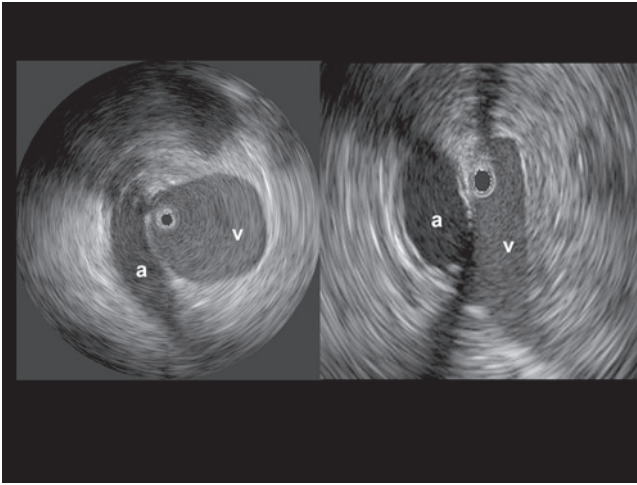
Images obtained by intravascular ultrasound (IVUS). The internal iliac artery (a) is seen crossing the external iliac vein (v) entering the pelvis. (left) No compression of the vein. (right) Significant compression of the vein, a distal compression lesion.
